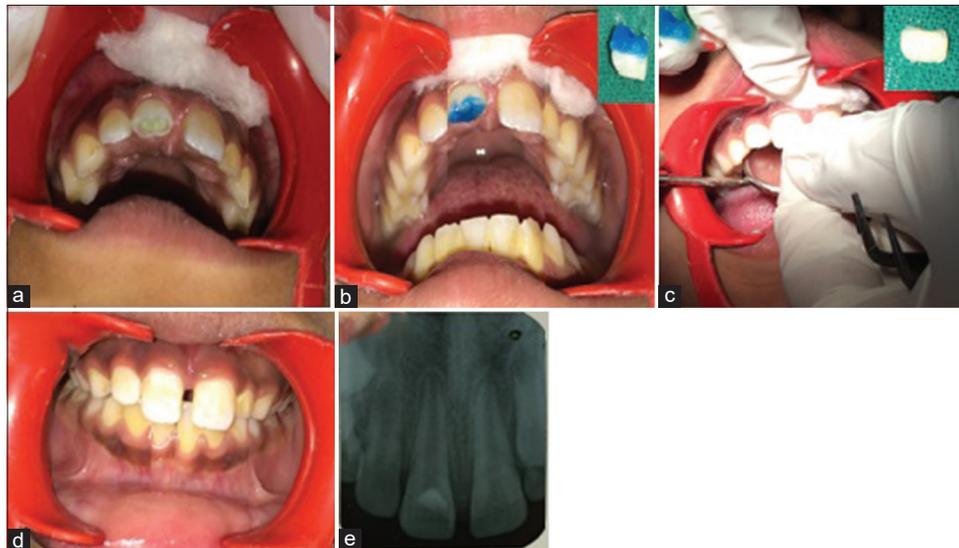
(a) Partial pulpotomy performed in 11 with MTA followed by GIC restoration; (b) Image showing etching of tooth and fragment; (c) Fractured fragment reattachment (d) Postoperative photograph after fracture reattachment; and (e) Postoperative radiograph immediately after reattachment.
